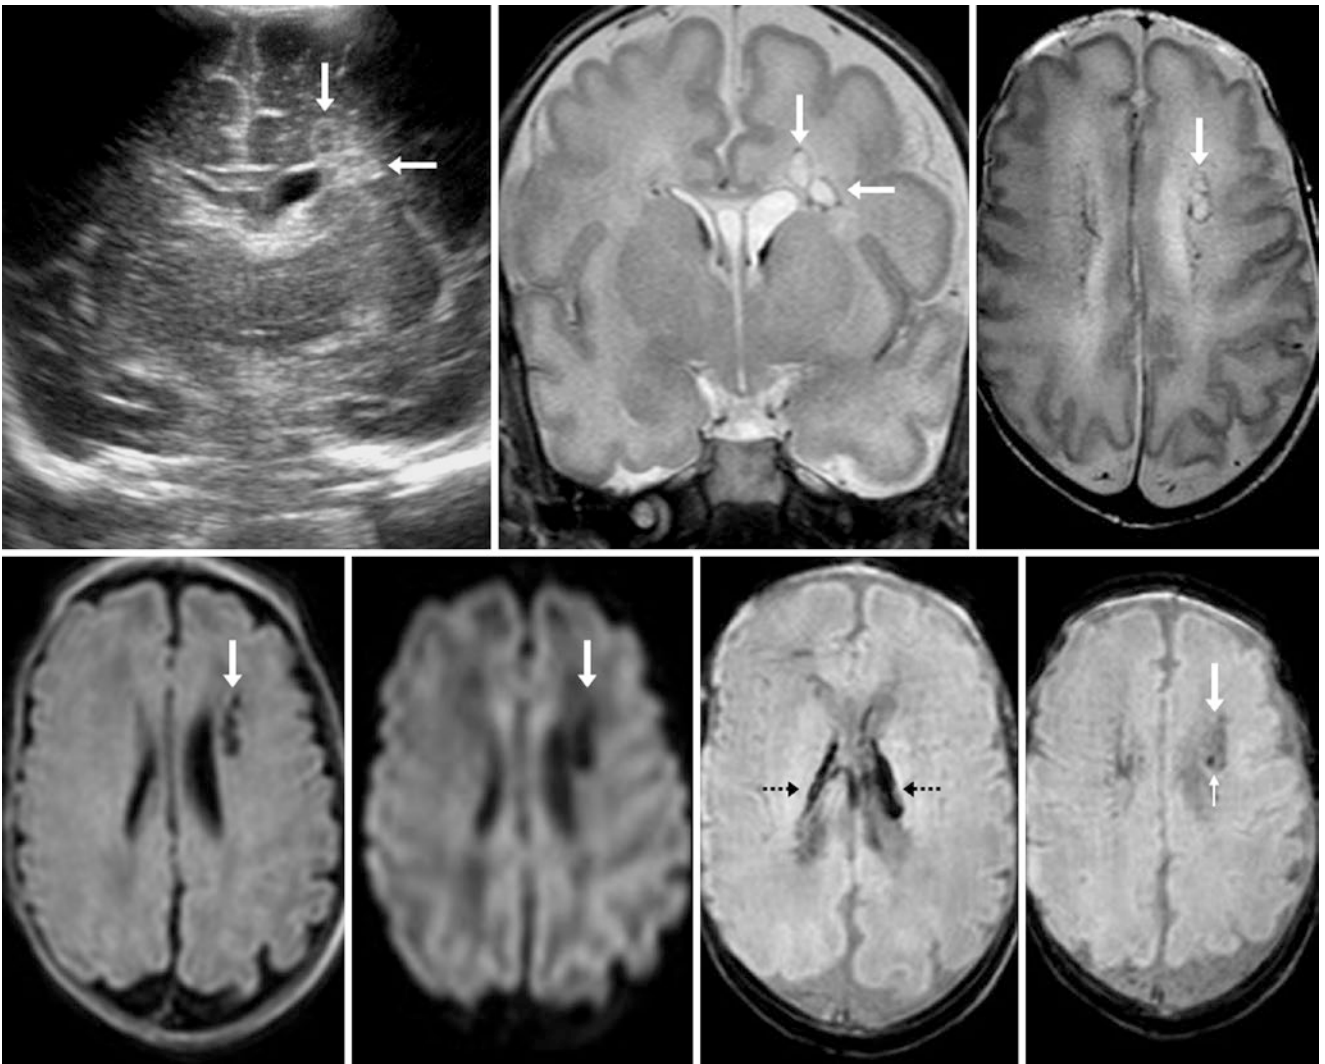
Comparison case of periventricular leukomalacia (PVL). A premature infant born at 34 weeks had left frontal PVWM abnormalities (arrows) on a coronal ultrasound (top left) and a grade 1 germinal matrix hemorrhage (GMH) within the left caudothalamic groove. On an MRI at term equivalent age 6 weeks later, coronal T2WI (top middle)
